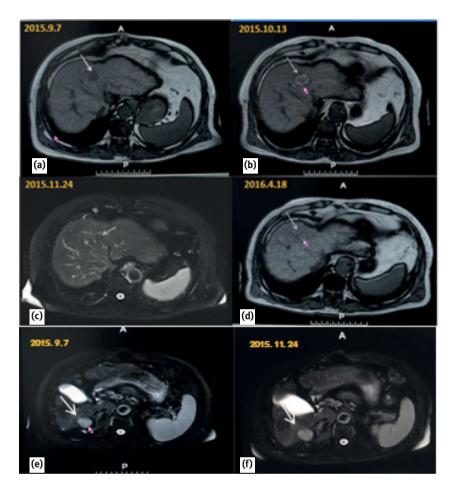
Magnetic resonance imaging of liver cancer showing the size and density of the upper tumor (arrow) before myoblast implantation (a) and at (b) 1 month, (c) 2.5 months, and (d) 7 months after implantation. Whereas (e) the noninjected control lower tumor (arrow) in the same liver increased in size in 2 months (f), the myoblast-injected T1 showed a significant decrease in size and density with time, indicating that the myoblasts and myotubes interrupted cancer proliferation and induced cancer apoptosis. (Reproduced with permission from Law et al. *Open Journal of Regenerative Medicine* 2017; 6:1–16. ©Scientific Research Publishing.)
